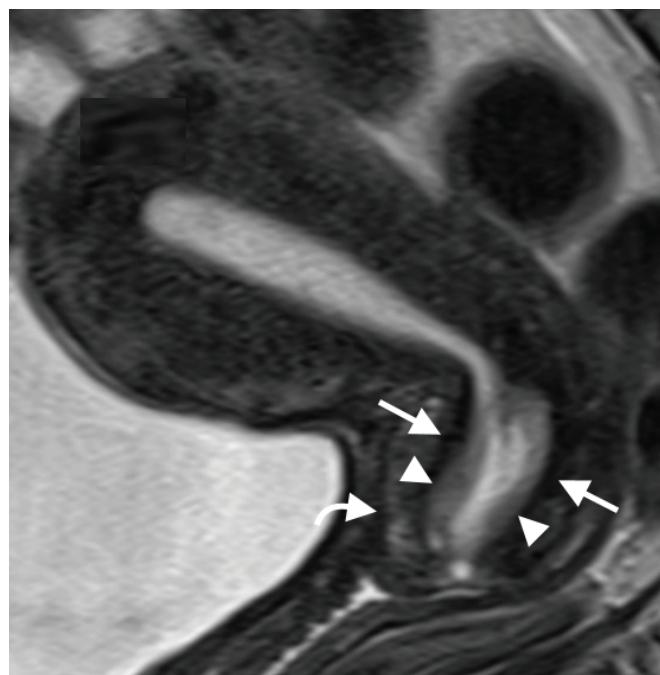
MRI scan of the cervix in longitudinal section showing the mucosal layer (arrowheads), the inner stromal layer (arrows) and the outer stromal layer (curved arrow).
